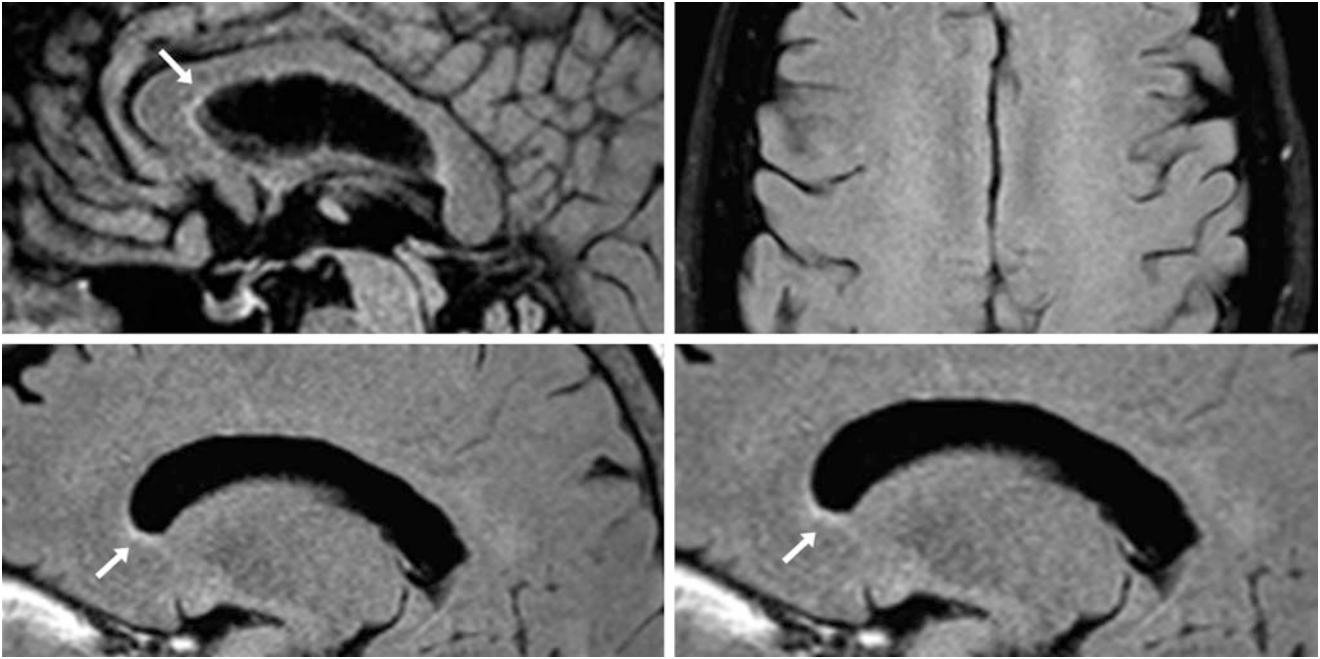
A 63 year old who underwent a 3T MRI (interpreted as negative) that demonstrated minimal, normal hyperintensity anteriorly (arrows) on a midline sagittal FLAIR image (top left) with normal axial
